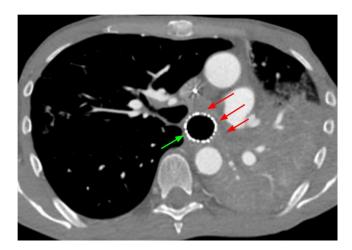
CTA chest axial view demonstrates that the esophageal stent (green arrow) extrinsically compresses and occludes the left mainstem bronchus (red arrows). There are significant postobstructive consolidative opacities in the left lung.
